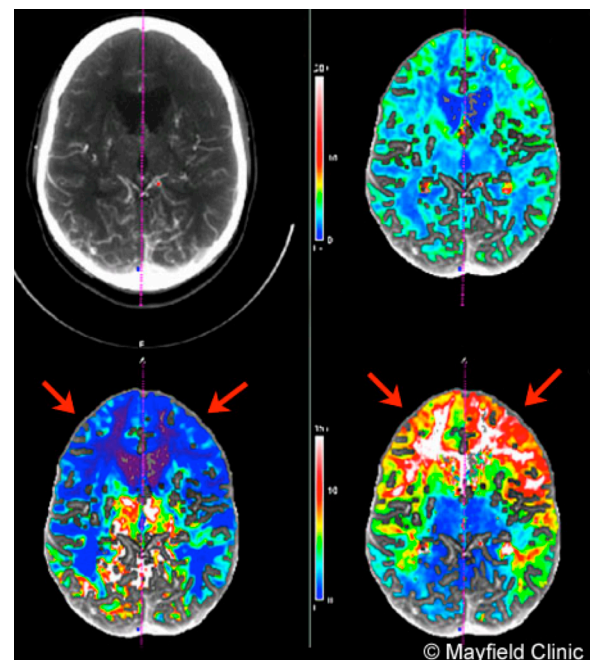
CT perfusion scans show areas of the brain that have decreased blood flow (red arrows) caused by moyamoya disease.
